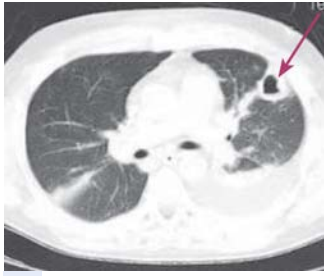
Spiral CT of the chest. Abscess of the left lung
